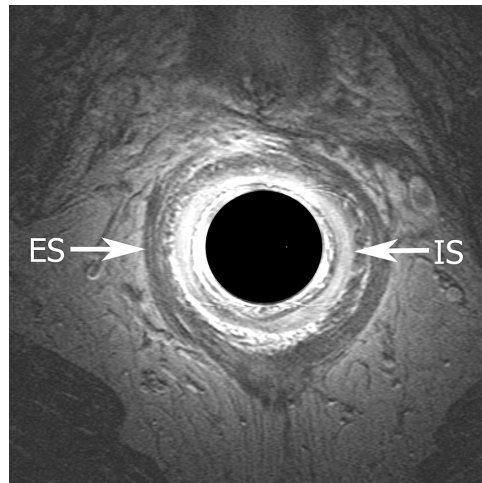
Transverse endoanal T2-weighted fast spin-echo (2500/70) MR image obtained from a 78-year-old man demonstrating normal anatomy at the mid-anal canal of the internal anal sphincter (IS) and external anal sphincter (ES). The top of the figure is anterior.
